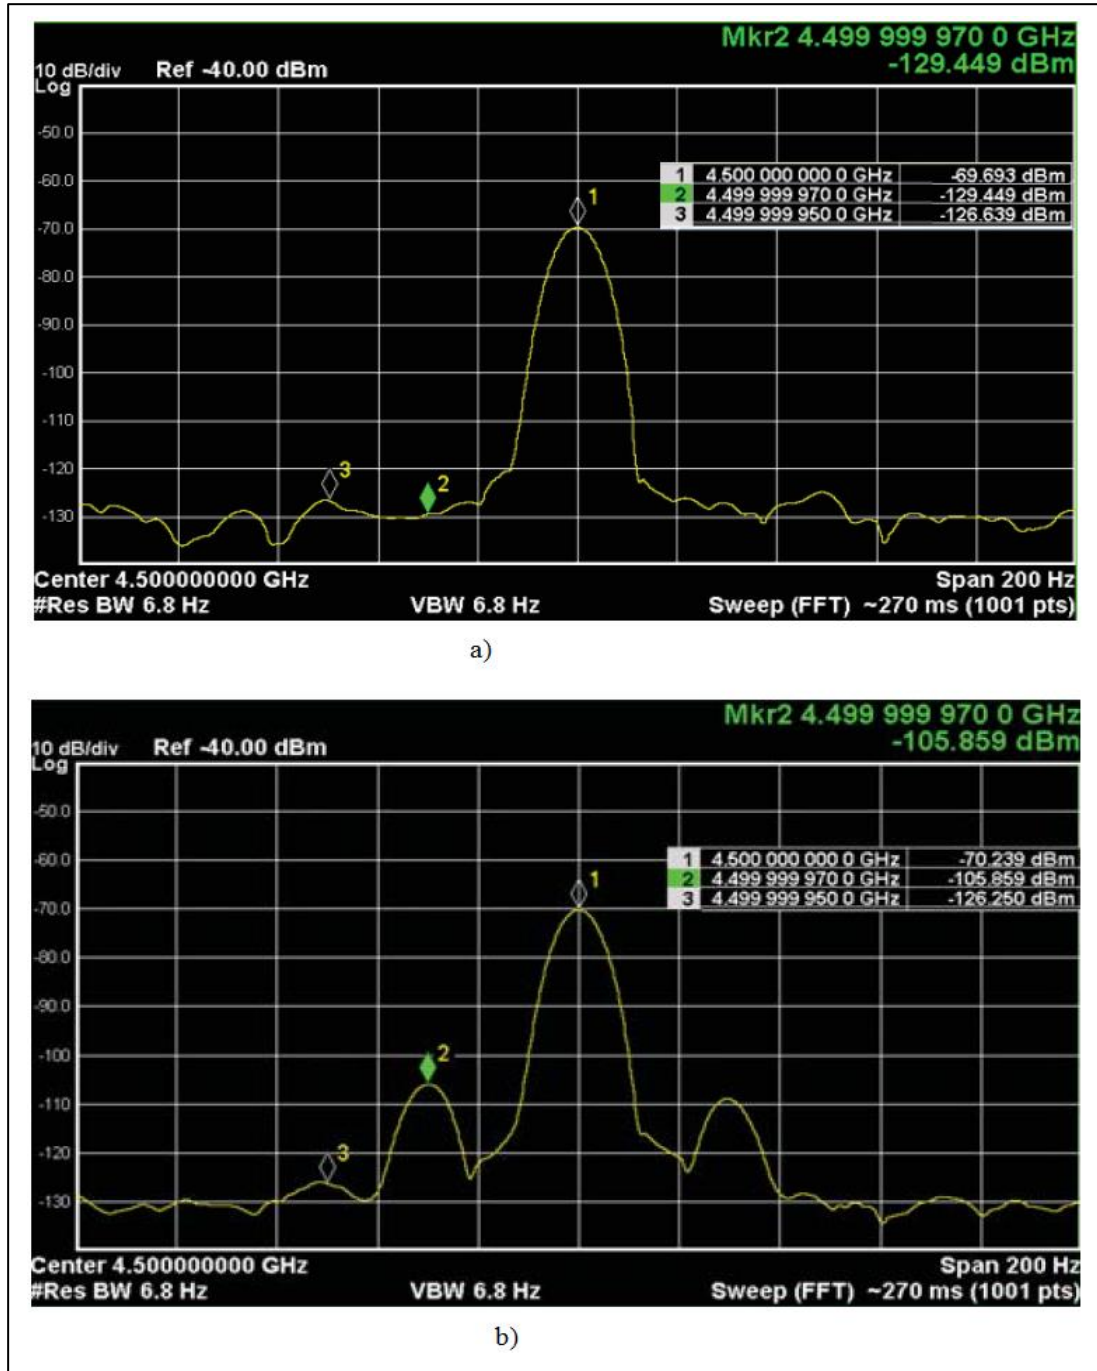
The spectrum of the received signal with main signal cancellation circuit: a) FUS transducer is OFF, b) FUS transducer is ON. $\omega_m=4.5$ GHz, $\Delta\omega=30$ Hz. Marker 1, 2, and 3 are located at the main signal frequency ω_m , Doppler signal frequency $\omega_m - \Delta\omega$ and the 50 Hz line frequency, respectively.
